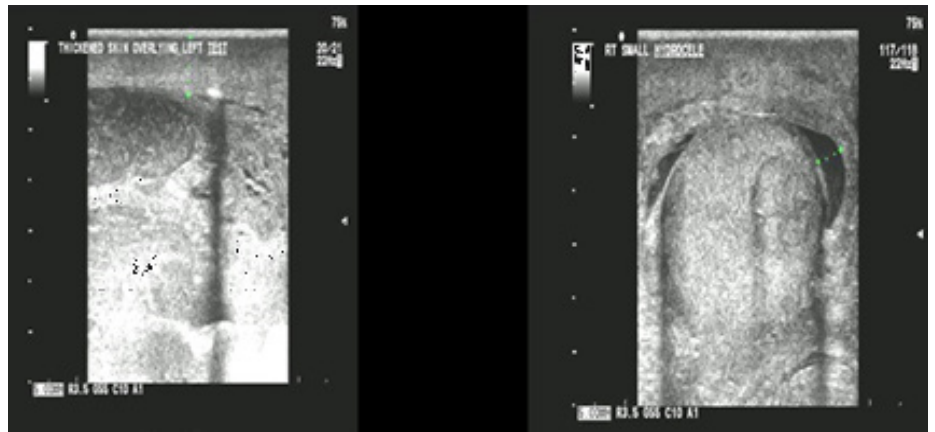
Mr. P.G.'s ultrasound scan images of the left and right testicles.
